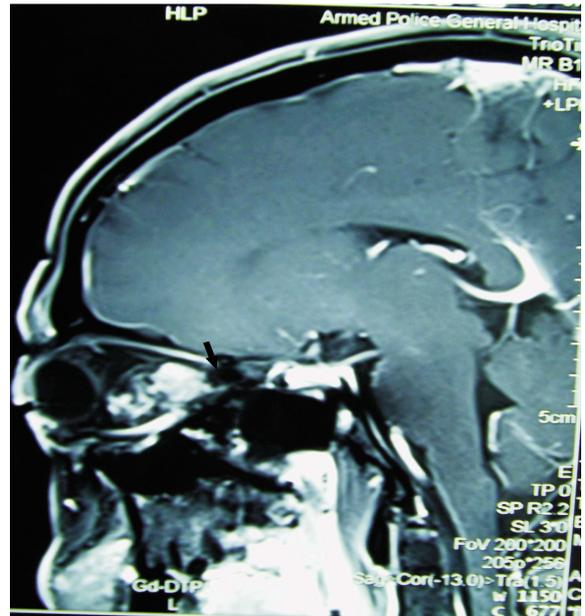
CT revealed smooth posterior margins of CH in case 4 with severe adhesion
